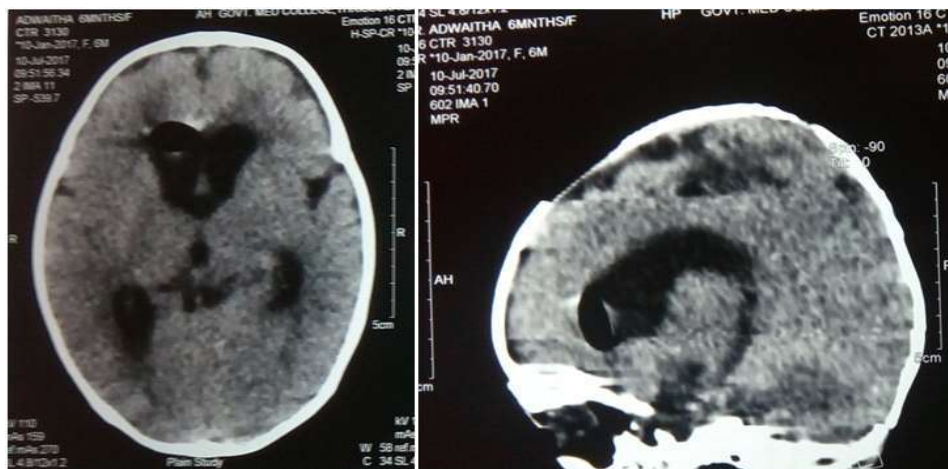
CT scan showing air in the cranial cavity
